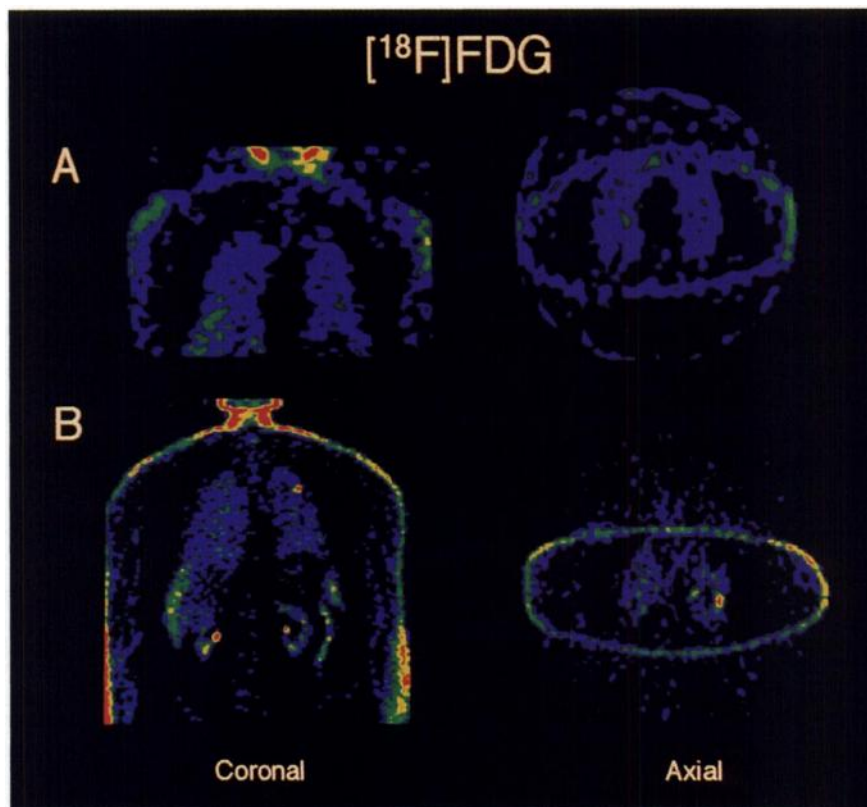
This 69-y-old man had solitary pulmonary nodule, 1-cm in size, in upper left lobe. Ring-PET study (B) shows focus of high FDG uptake within lesion, which is not identified on DH-PET study (A).
